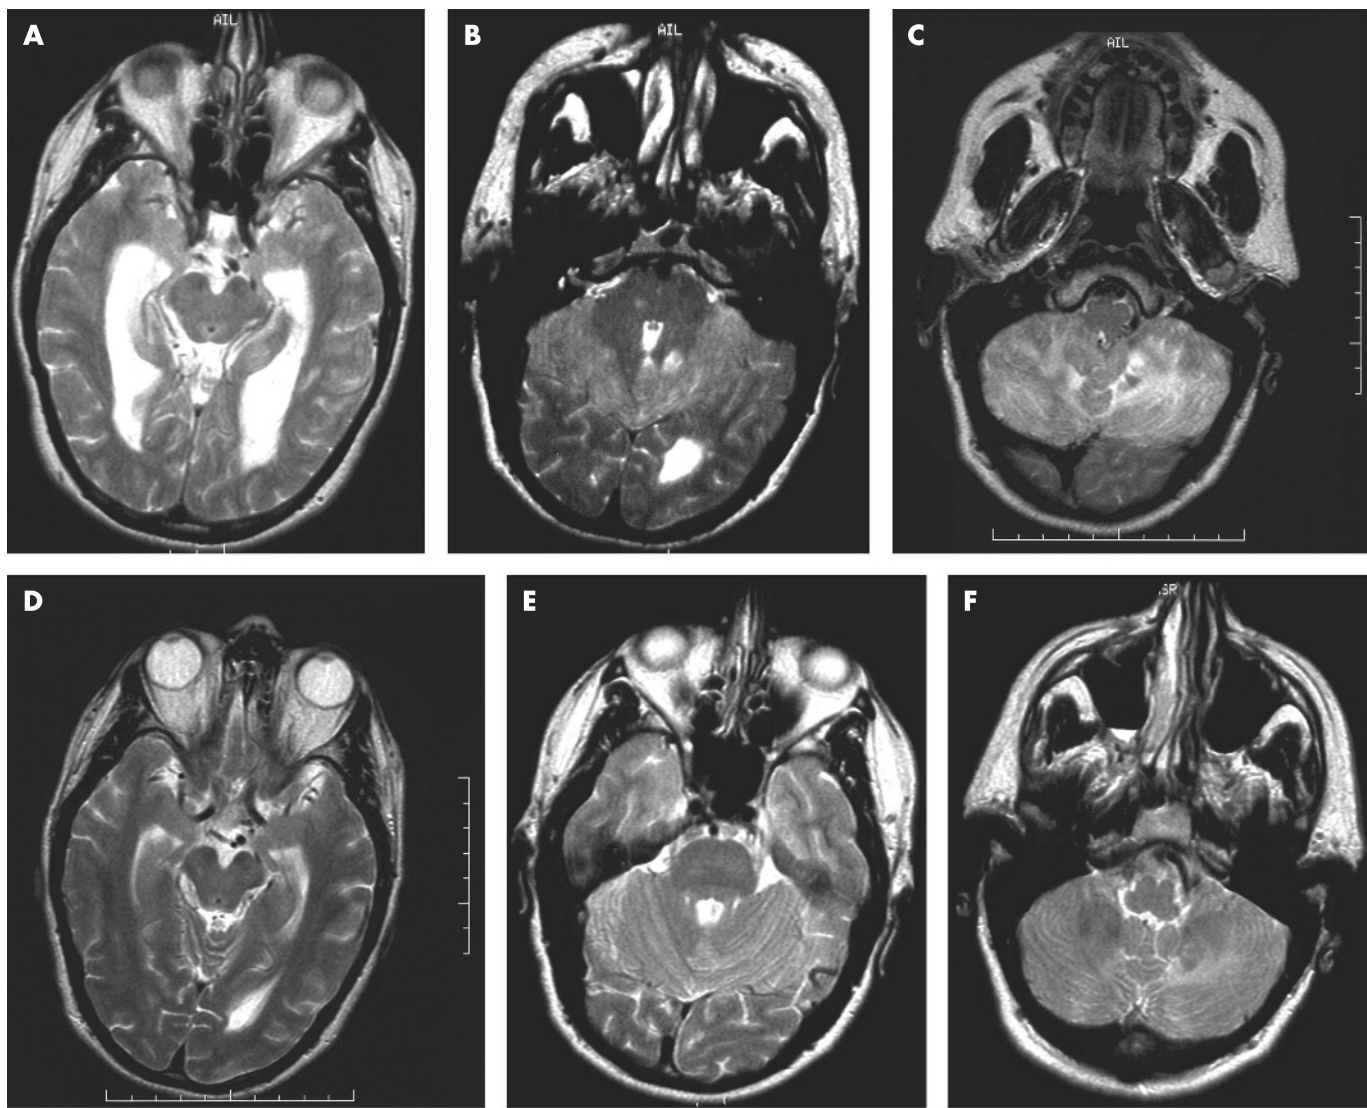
Sample magnetic resonance images of the brain acquired in the axial plane, with mainly T2 dependent contrast (repetition time 3320 ms, effective echo time 108 ms). Images (A–C) were made before treatment; uncontrolled blood pressure. Images (D–F) were made 5 days later. The pretreatment images show dilation of the lateral ventricles, swelling and signal change in the cerebellar white matter and compression of the fourth ventricle. The post-treatment images show resolution of the hydrocephalus and compression of the fourth ventricle and almost complete clearing of the signal abnormalities in the cerebellar white matter.
